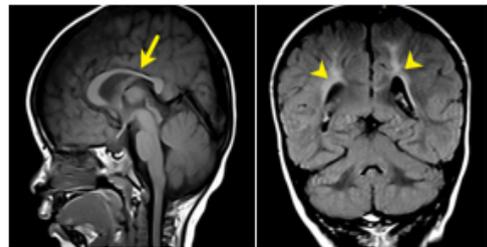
Sagittal T1 WI and coronal FLAIR images of a 1yr old female with low birth weight history shows periventricular hyperintense signal and mild thinning of the posterior part of body of corpus callosum.
